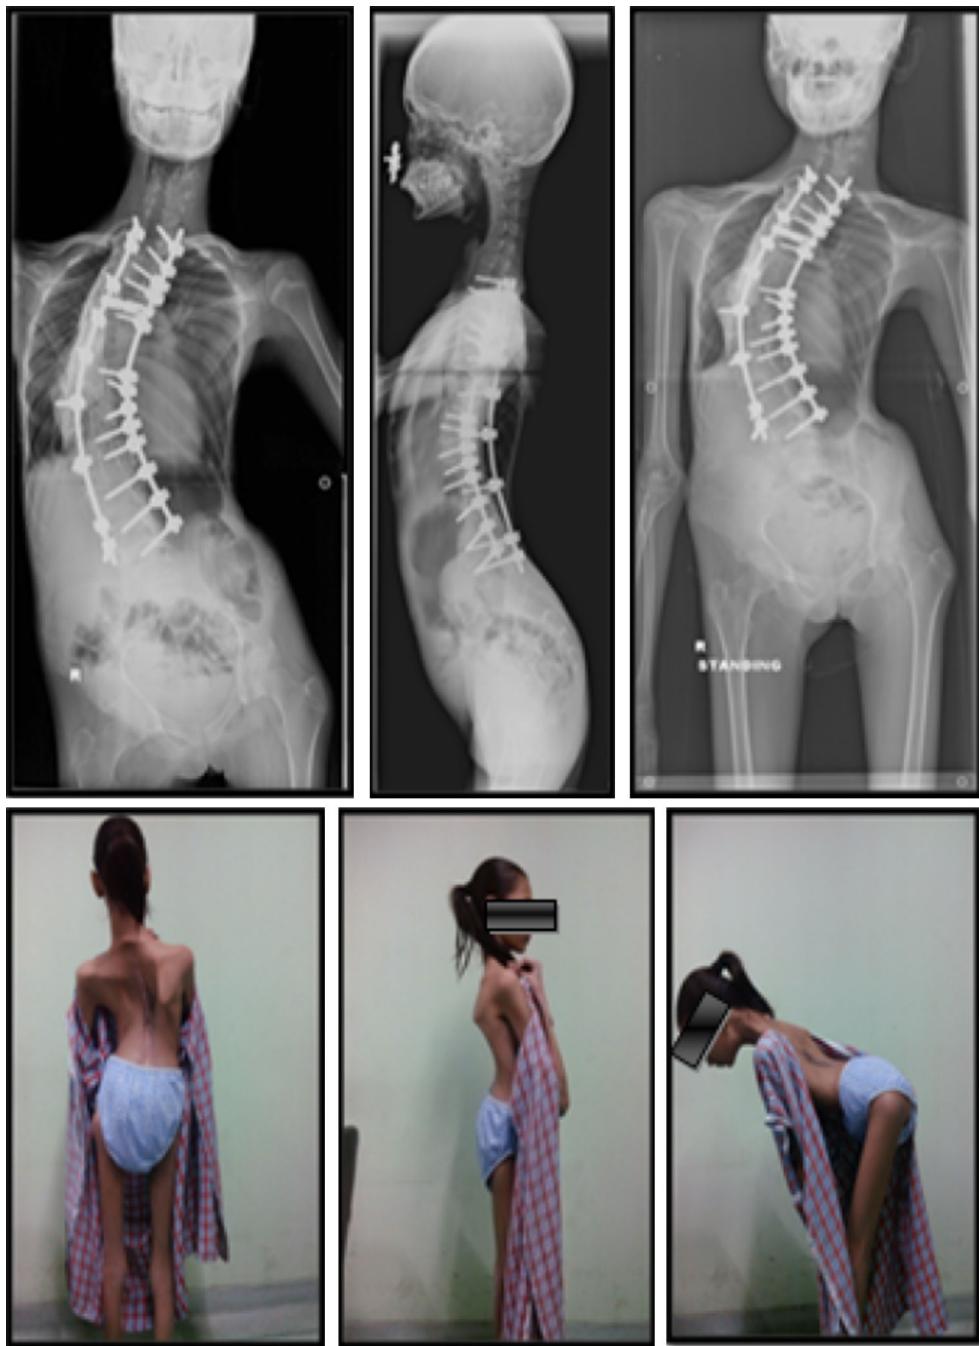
Halo-gravity and halo-femoral traction followed by posterior release and periapical osteotomies with halo-pelvic distraction. Note the amount of correction at the end of 4 weeks of halo-pelvic distraction
